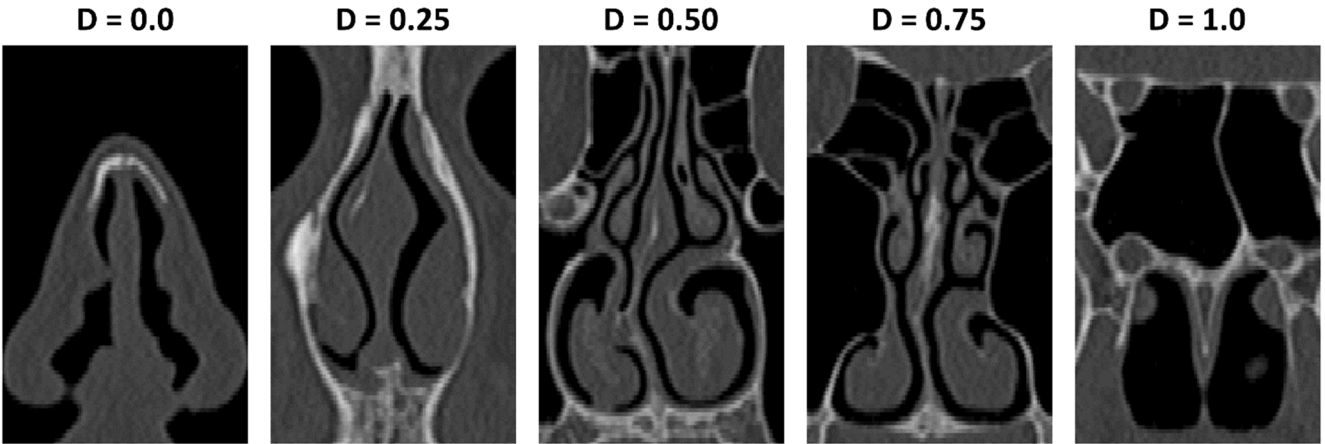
Pre-surgery coronal CT of NAO patient. The relative distance along the nasal cavity (D) is shown at the top of each panel. The posterior end of the nostrils are defined as $D=0$ and the choana (posterior end of the septum) is defined as $D=1$.
